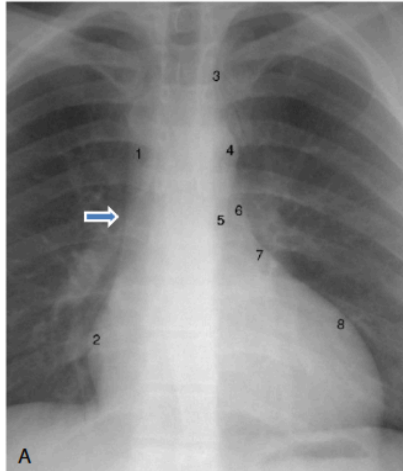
Normal chest radiograph. A, Posteroanterior view. Arrow indicates the ascending aorta. 1, Superior vena cava; 2, right atrium; 3, subclavian artery; 4, aortic knob; 5, descending aorta; 6, pulmonary trunk; 7, left atrial auricle; 8, left ventricle.
